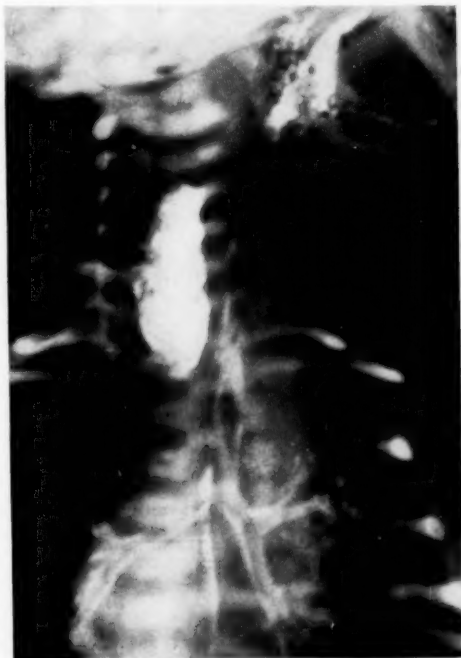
(Case 1, P. H.) Roentgenogram of the lipiodol-filled diverticulum.
